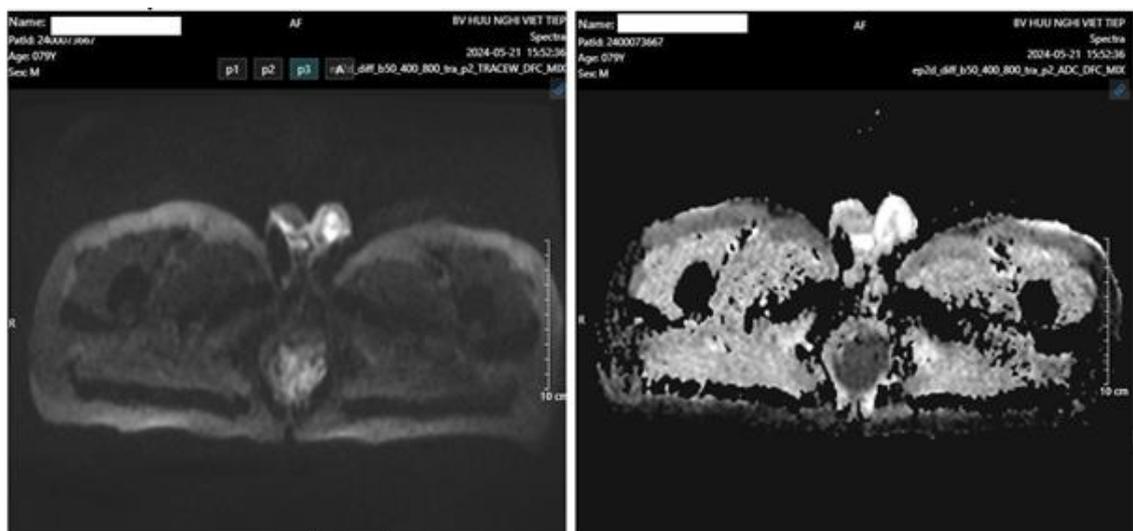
Diffusion-weighted imaging (DWI) sequence
